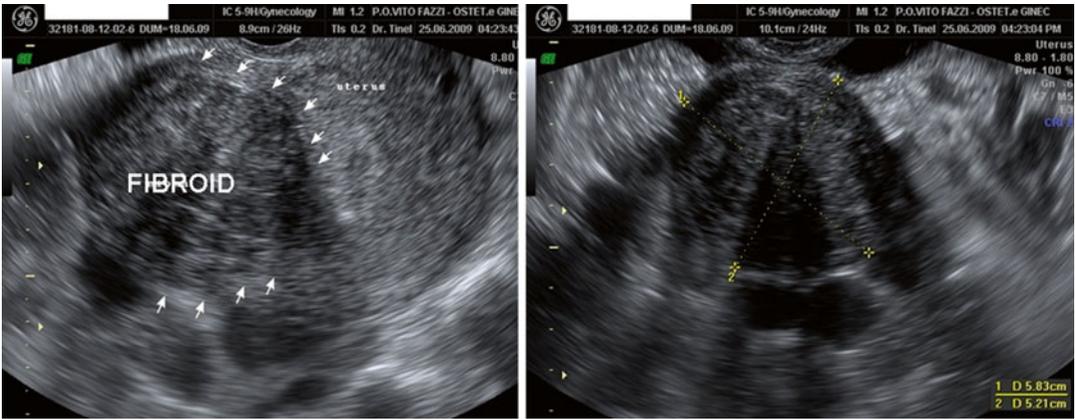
Uterine sonography showing, on the *left*, an intramural fibroid and, on the *right*, a pedunculated fibroid
